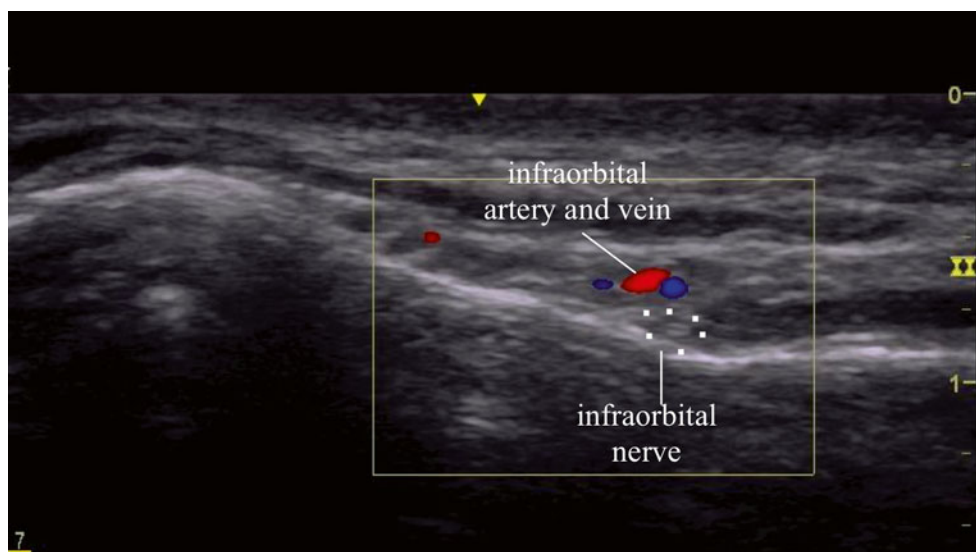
Ultrasound infraorbital image (Image courtesy of David Spinner, MD)
